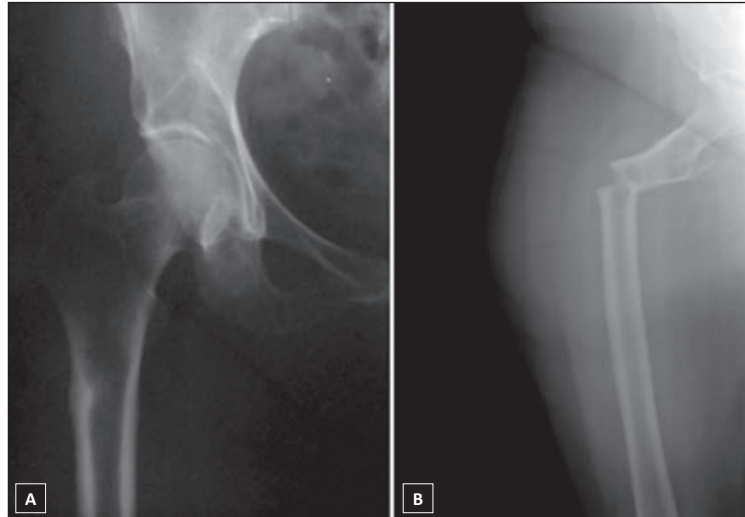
(A) Plain radiograph shows cortical hypertrophy in the right subtrochanteric region. (B) Right femur with subtrochanteric fracture at the same site in which bone hypertrophy was seen before.
